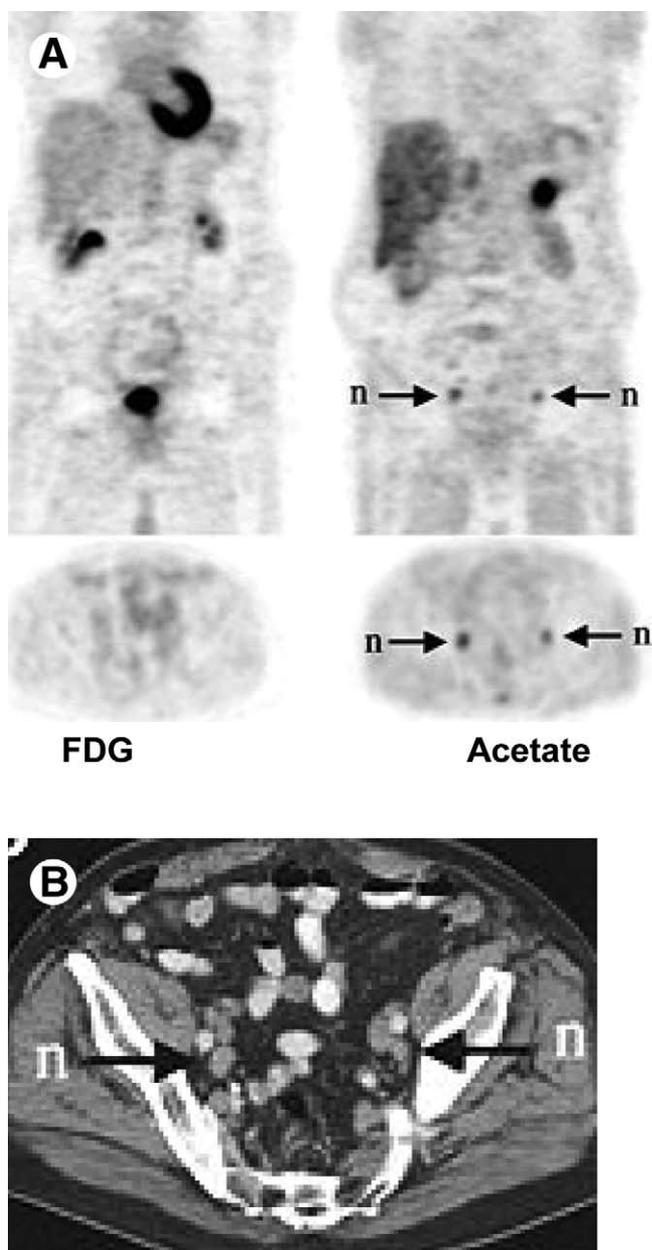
(A) FDG and ^{11}C acetate PET scan in 73-year-old male with PSA relapse (9.1 ng/mL) approximately 2 years after external beam RT with curative intent. FDG images (left panel) show no abnormal tracer uptake, whereas ^{11}C acetate images (right panel) clearly demonstrate abnormal tracer uptake in pelvic lymph nodes. (B) CT shows mildly enlarged pelvis lymph nodes. (Images reprinted by permission of the Society of Nuclear Medicine from Oyama et al.³⁸).
